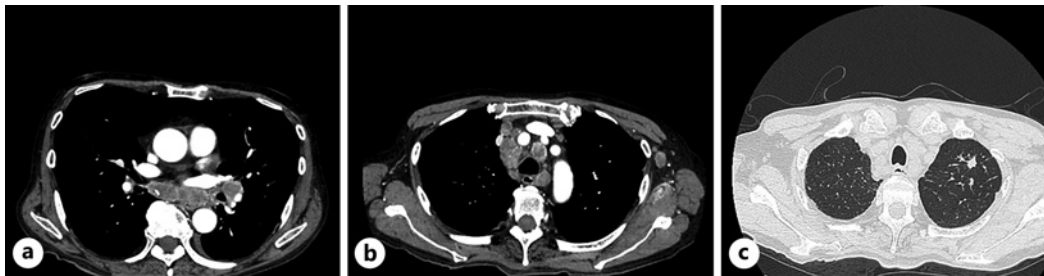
Chest enhanced CT detected left hilar (a) and mediastinal lymphadenopathy (b) and an irregularly shaped nodule in the left upper lobe (c). CT, computed tomography.
